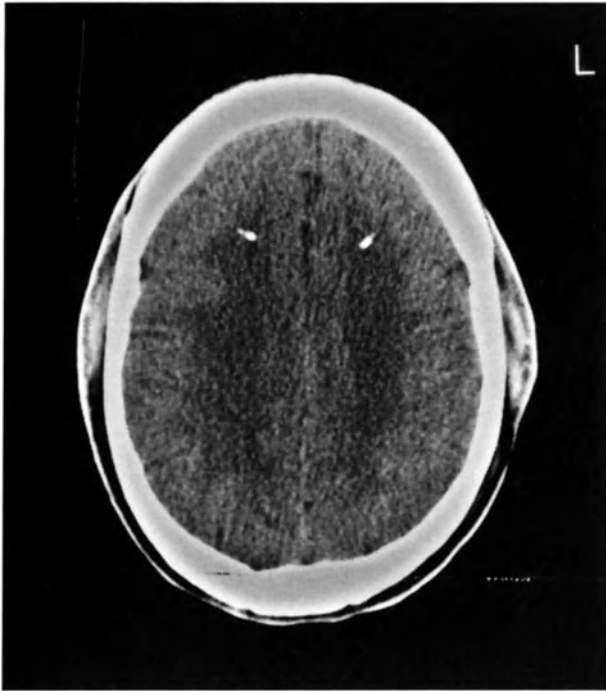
CT scan showing the intraparenchymal position of the tips of the bifrontal ICP probes in patient 6
